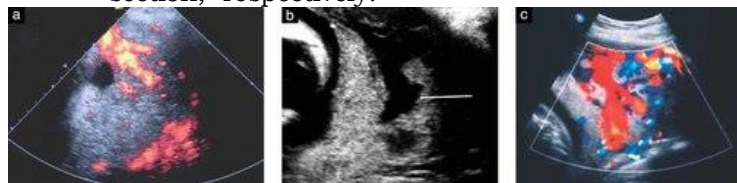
Placenta accreta sinuses. (A) Color Doppler picture of a sinus with a tornado form. (b) Grayscale picture of sinus formed like a tornado (arrow). (c) Color Doppler picture displaying many sinuses on the placenta accreta.
